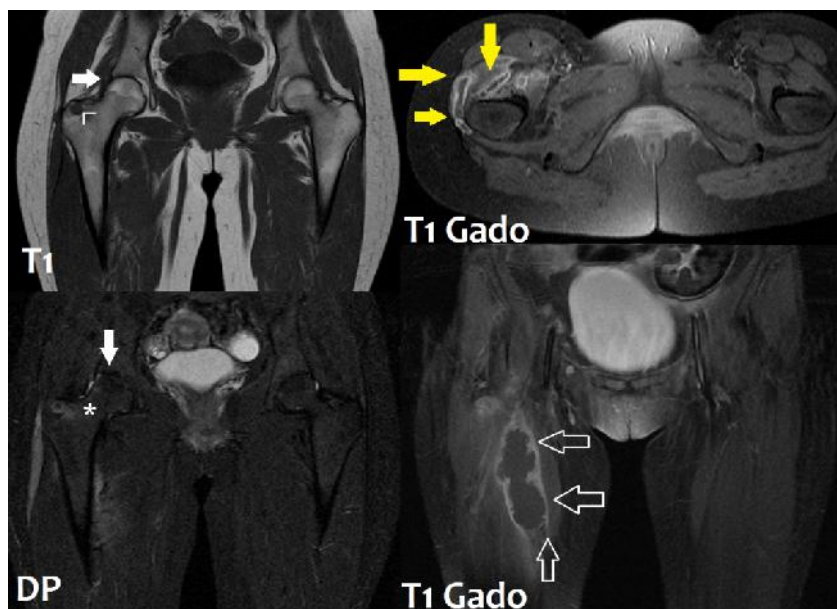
Hip MRI showing a small great trochanter hypo-intense T1 lesion (arrowhead) with surrounding edema (asterisk), soft tissue large collections (empty arrows), and trochanteric bursitis (yellow arrows). Note the integrity of the coxo-femoral joint (white arrows).
